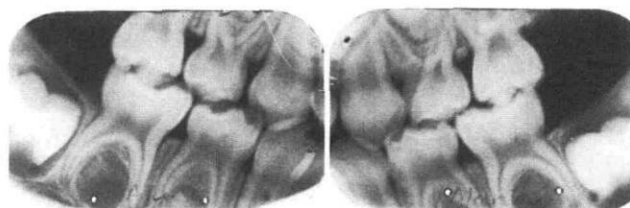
Bite-wing radiographs of Patient 10 showing normal appearance of pulp chambers and thicknesses of enamel and dentine.
